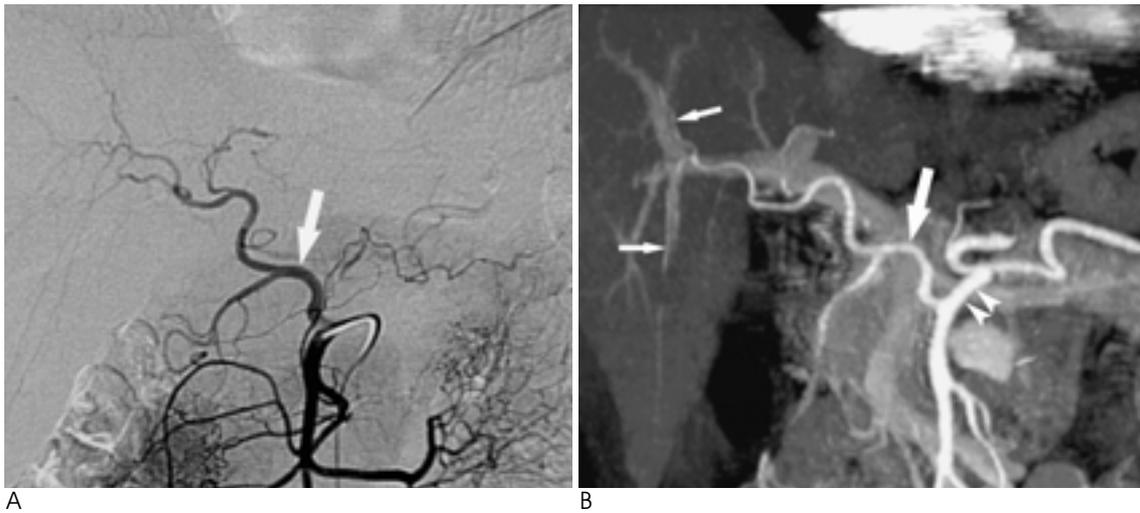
Type IX of Michels classification. Oblique coronal three-dimensional CT angiogram (B) shows well common hepatic artery (arrow) arising from superior mesenteric artery (arrowheads). 3DCT angiogram (B) well demonstrates 3rd branches (small arrows) of hepatic artery, and image quality of 3DCT is estimated as excellent degree. Conventional angiogram (A) shows common hepatic artery (arrow) arising from superior mesenteric artery.
